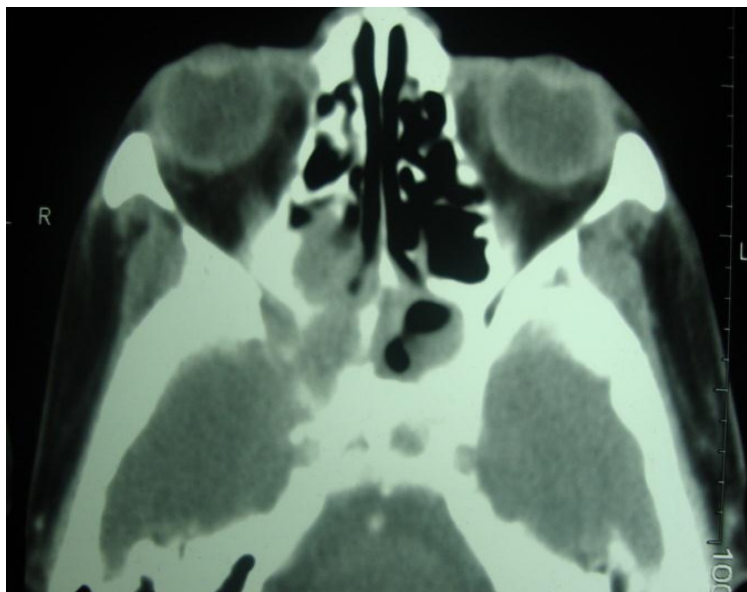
CT Axial View showing soft tissue mass involving lateral wall of the right ethmoidal and sphenoid sinuses and extending posteriorly into the optic canal and orbit.
